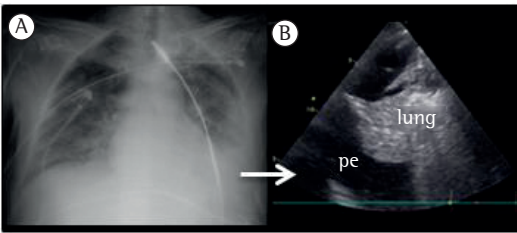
X-ray (in A) and ultrasound (in B) revealing pleural effusion and lung collapse. pe: pleural effusion.
